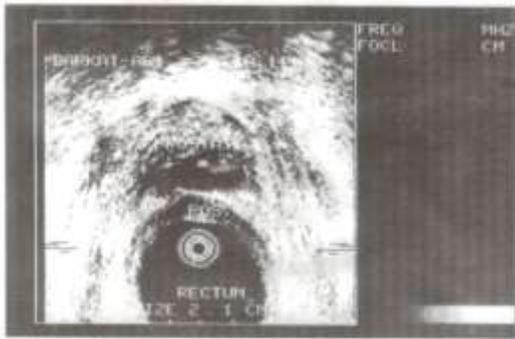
Endorectal axial sonogram showing prostatic cancer. Transrectal ultrasound of the prostate in axial orientation demonstrates a hypoechoic area in the posterior portion of the prostate.
